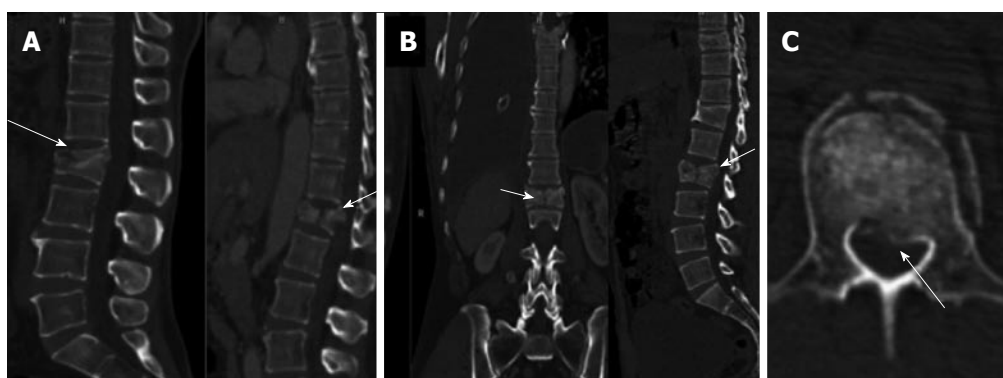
Type A3 compression injuries-burst fractures. Sagittal computed tomography (CT) image (A), sagittal and coronal CT images (B), sagittal and axial CT images (C) show (A) incomplete burst (A3.1) (B) burst-split (A3.2) and (C) retropulsion of fracture fragments suggesting a complete burst injury (A3.3).
